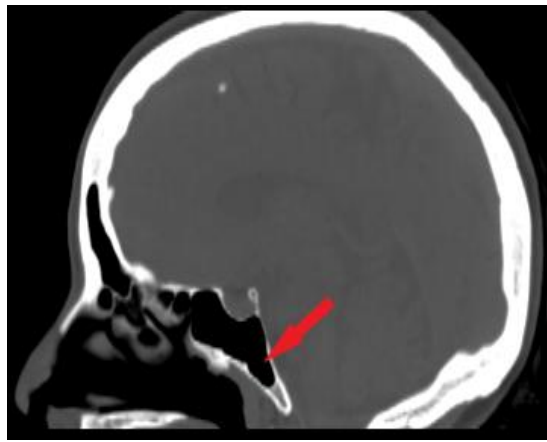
CT scan sagittal view shows clivus pneumatization.
